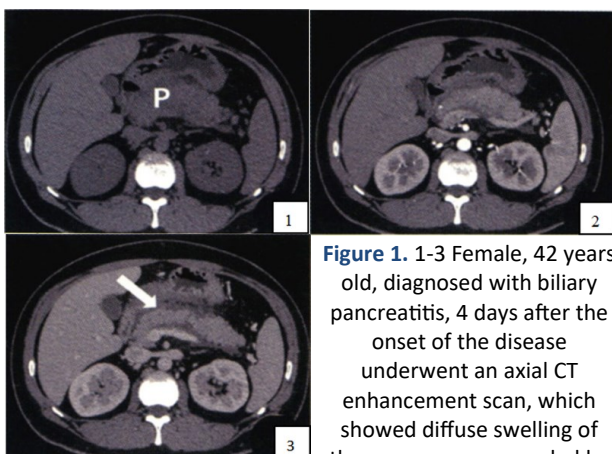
1-3 Female, 42 years old, diagnosed with biliary pancreatitis, 4 days after the onset of the disease underwent an axial CT enhancement scan, which showed diffuse swelling of the pancreas, surrounded by more homogeneous fluid density shadows, and a MCTSI score of 4.
